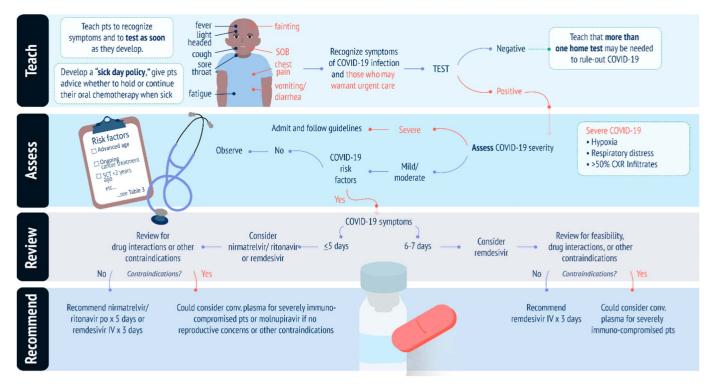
Approach to outpatient management of patients with blood cancer and COVID-19. conv., convalescent; CXR, chest x-ray; IV, intravenously; po, orally; pts, patients; SCT, stem-cell transplant; SOB, shortness of breath.
